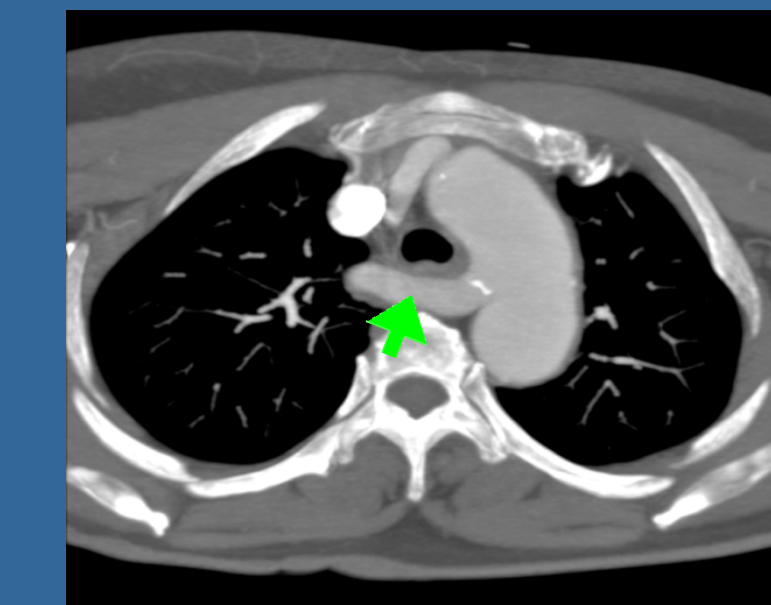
Arteria lusoria(arrow) on CT angiography
